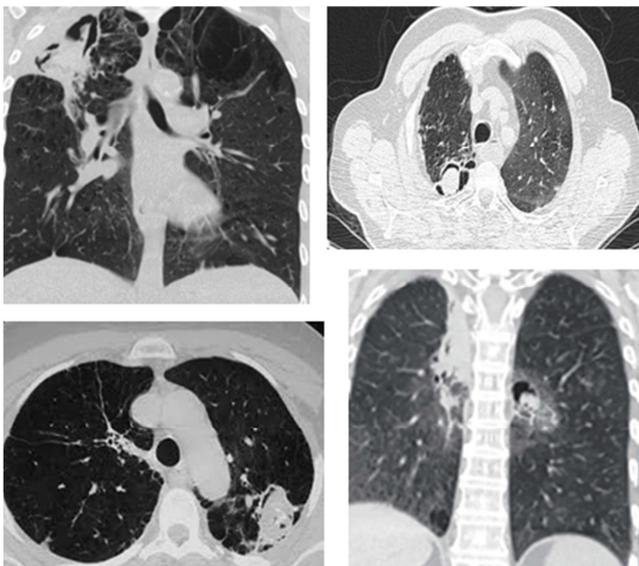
(2, a, b, top left & right) CT chest sagittal and coronal views showing right apical cavitory lesion containing fungus ball. (c, d bottom left & right) left upper lobe aspergilloma seated at posterior segment.
